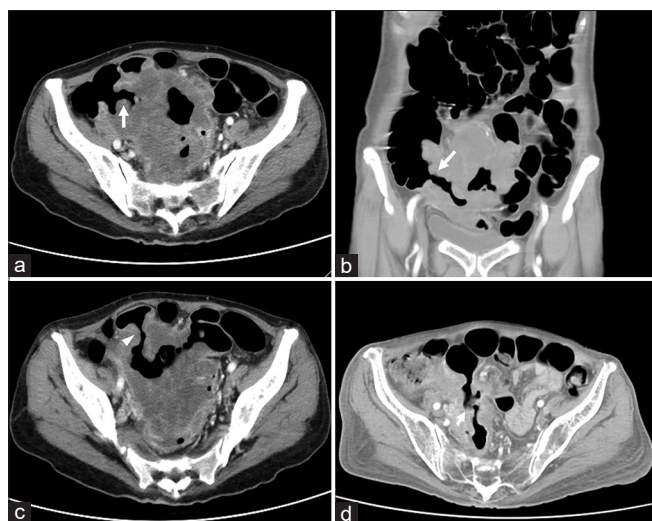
A computed tomography scan revealed fistula formations between the cecum and sigmoid colon (arrow) (a and b) and between the ileum sigmoid colon (c) (arrowhead). The tumor shrinkage compatible with a partial response was achieved after neoadjuvant concurrent chemoradiotherapy (d). Note that the ileo-sigmoid colon fistula remains despite tumor regression (arrow)
